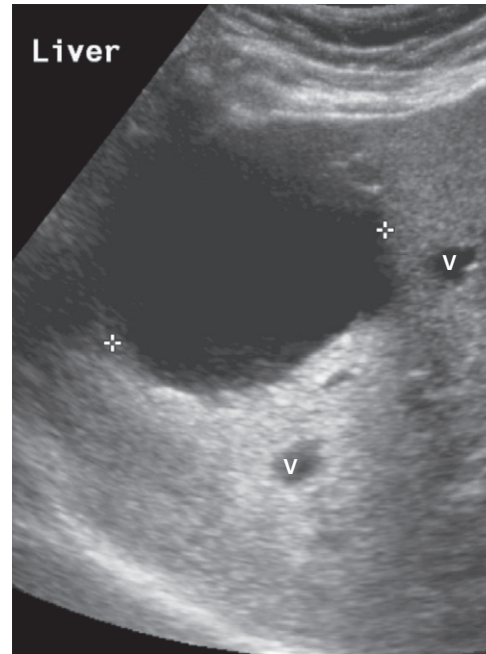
Ultrasound of a benign cyst. Note the imperceptible wall and absence echoes within the cyst. There is also posterior acoustic enhancement (increased echogenicity of structures deep to the cyst) secondary to enhanced transmission of the ultrasound waves through the water density of the cyst. V, hepatic veins.
